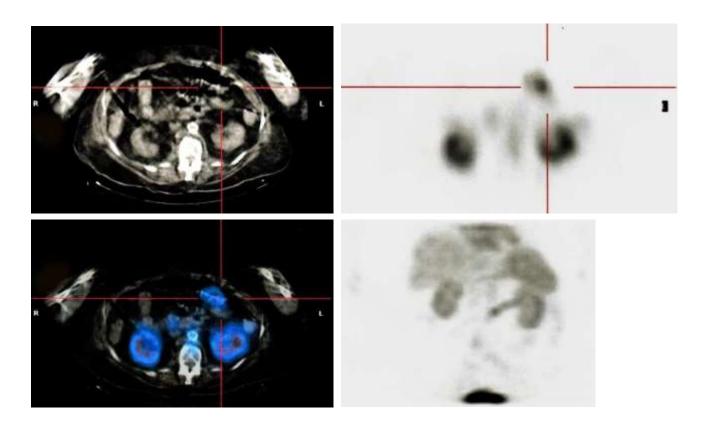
Scintigraphy with erythrocytes labeled with Technetium 99m coupled with abdominal CT scan. It was a hemorrhagic micro lesion of the posterior face of the left transverse colon.
